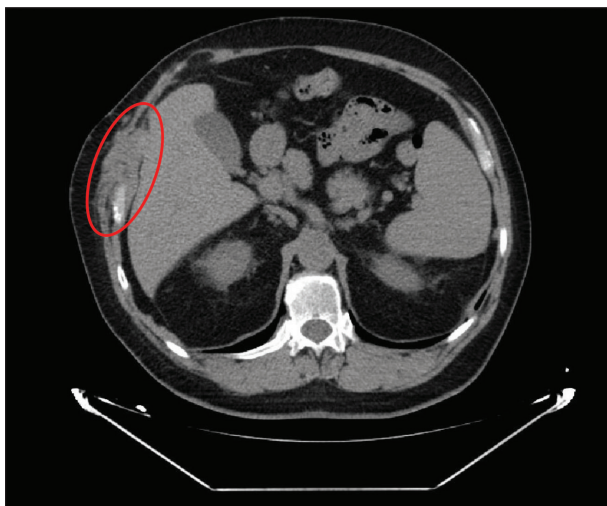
A computed tomography scan of the chest: tumor of the right anterolateral chest wall, dense tissue tumor arising from the anterolateral chest wall
